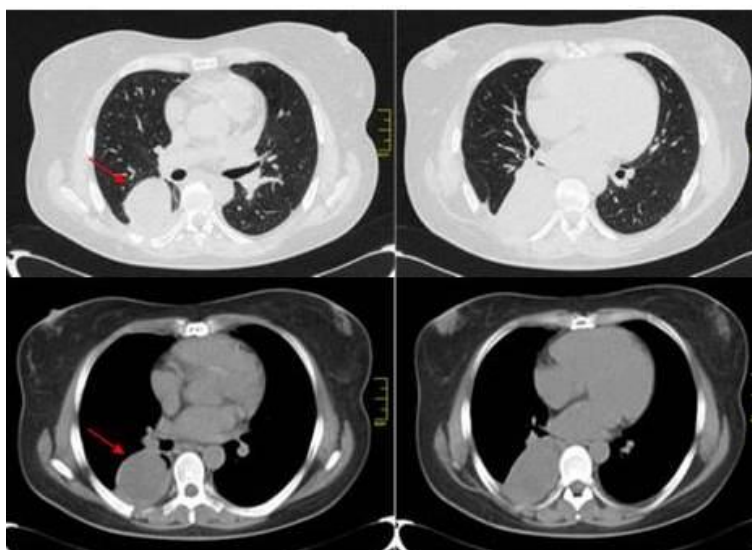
Chest CT: image of a mass with well-defined margins and a rounded morphology, measuring 9 cm x 7 cm, with attenuation values between 23–43 HU, isodense, and smooth contours in contact with the chest wall and subpleural space. Absence of lymphadenopathy in the mediastinal, supracarinal, and perihilar regions
